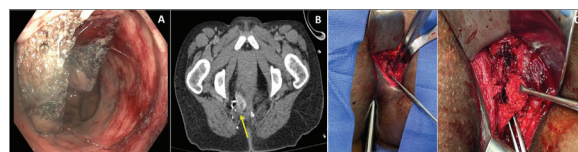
(A) Endoscopic image of retained rectal VAC sponge. (B) CT image demonstrating retained foreign body in presacral space after endoscopic removal of intraluminal component. (C) Intraoperative photos showing apparent wound VAC sponge being removed from presacral space via Kraske procedure.
